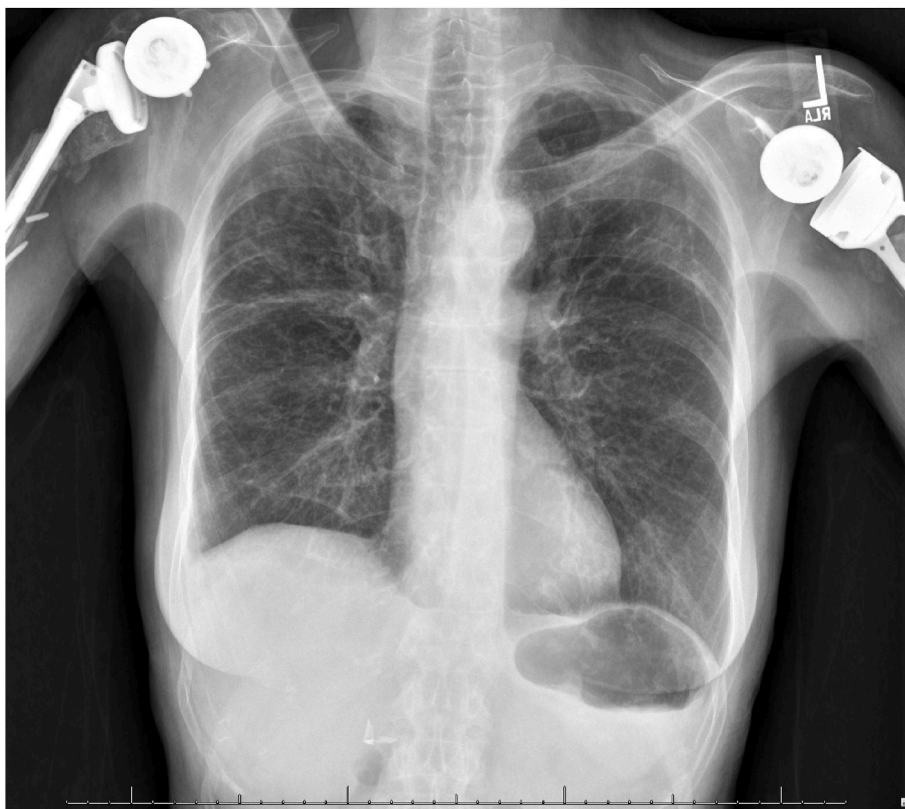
Day 78 Ambulatory post-antibiotic chest x-ray.
